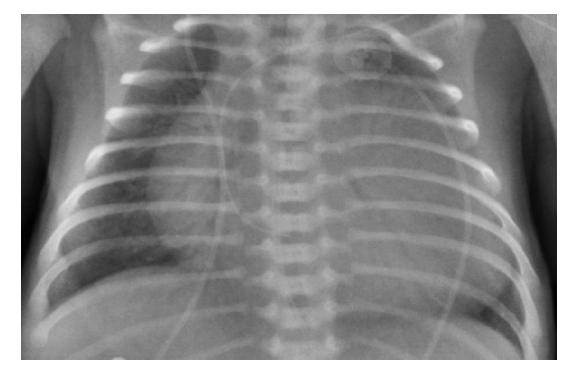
Anteroposterior chest X-ray, Cardiomegaly with catheter tip in the right atrium.
